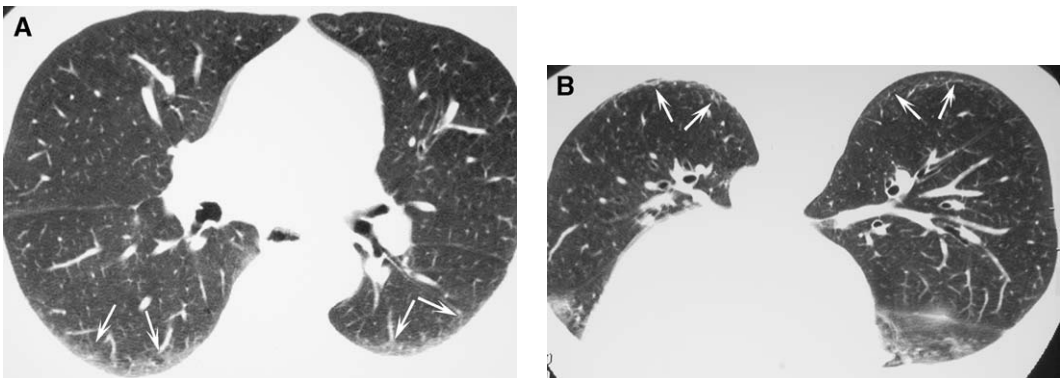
Value of prone HRCT imaging. (A) Axial supine HRCT images shows reticular opacity in the posterior lungs (*arrows*), which could represent either dependent density (atelectasis) or pulmonary inflammation or fibrosis. (B) Axial prone HRCT image shows persistence of the posterior reticular opacities (*arrows*), consistent with the presence of pulmonary inflammation or fibrosis.
